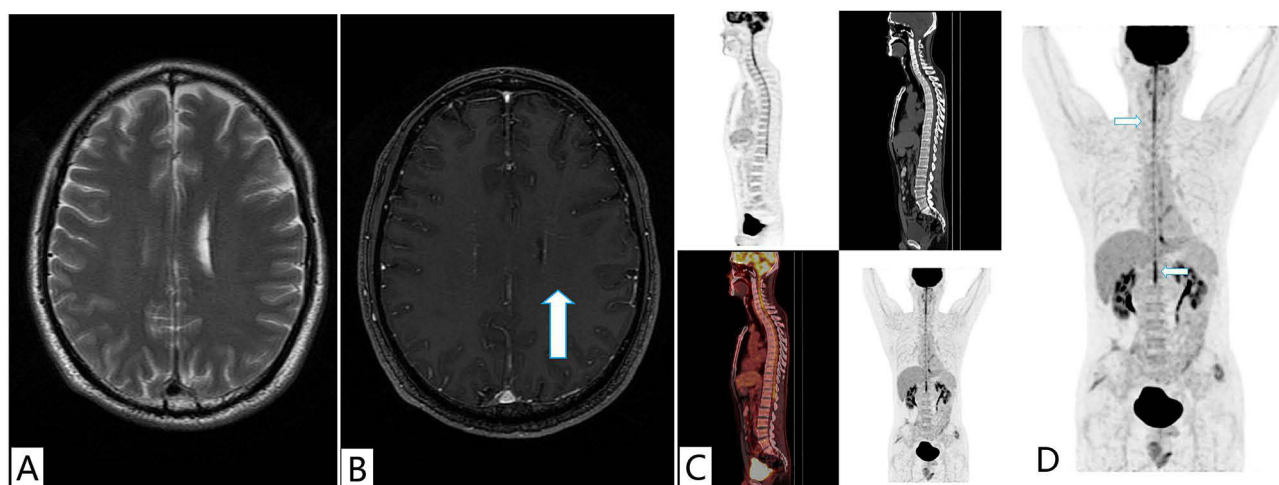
MRI images of patient #1, a male, 47 years old, with headache, fever, weight loss, unsteady walking, dysuria, ataxia, tremors in hands, and numbness of the fingertips of both hands. (A) Plain MRI scanning of the brain showing normal signal; (B) Contrast-enhanced MRI scanning of the brain showing linear enhancement (arrow) beside ventricle; (C and D) PET-CT showing diffuse hypermetabolism from medulla to lumbar spinal cord (arrow).
